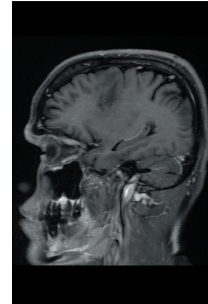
Sagittal contrast MRI image of brain showing a non-enhancing lesion in the right frontal lobe in a biopsy proven case of primary CNS lymphoma.
